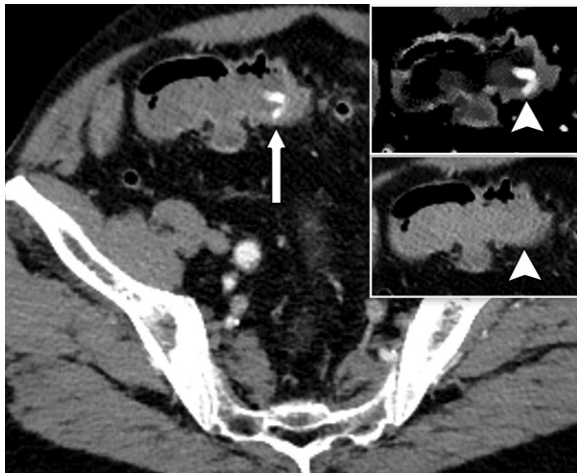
Active bleeding in the sigmoid colon from diverticulosis on a single-phase dual-energy CT image during the portal venous phase in an 83-year-old man with abdominal pain and blood in the stool. Axial mixed (blended) dual-energy CT image shows foci of increased attenuation within the sigmoid colon (arrow in main image), which is also present in the iodine map image (arrowhead in top inset), but not present in the virtual noncontrast image (arrowhead in bottom inset), confirming contrast extravasation. There is also sigmoid diverticulosis.
